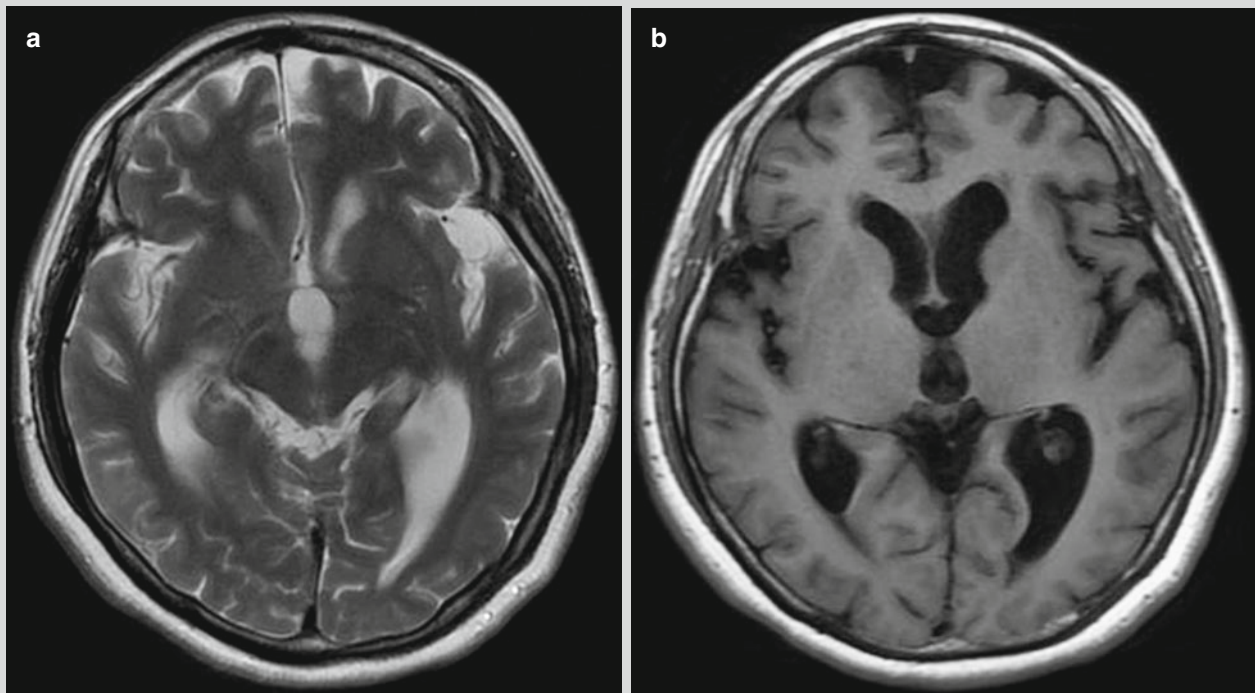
Neurological brucellosis. (a, b) MR imaging demonstrates dilated ventricular system of the brain, suggesting hydrocephalus
